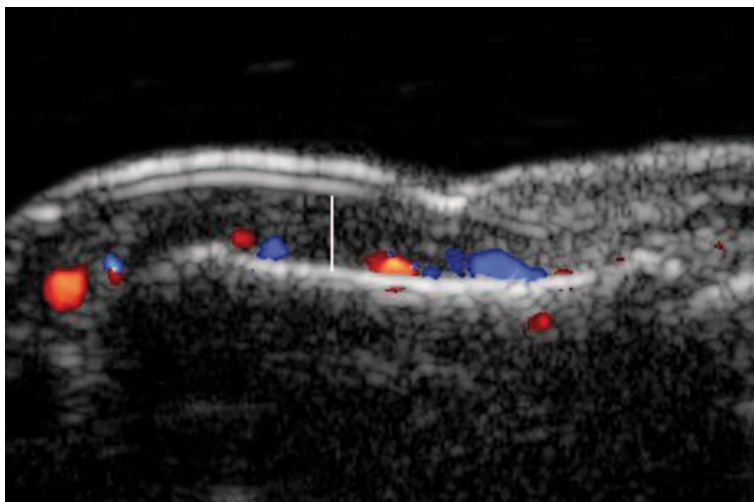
Rheumatoid arthritis. Color Doppler ultrasound of the nail demonstrated upward displacement of the unguis plaques due to thickening of the nail bed (*vertical white line*)
